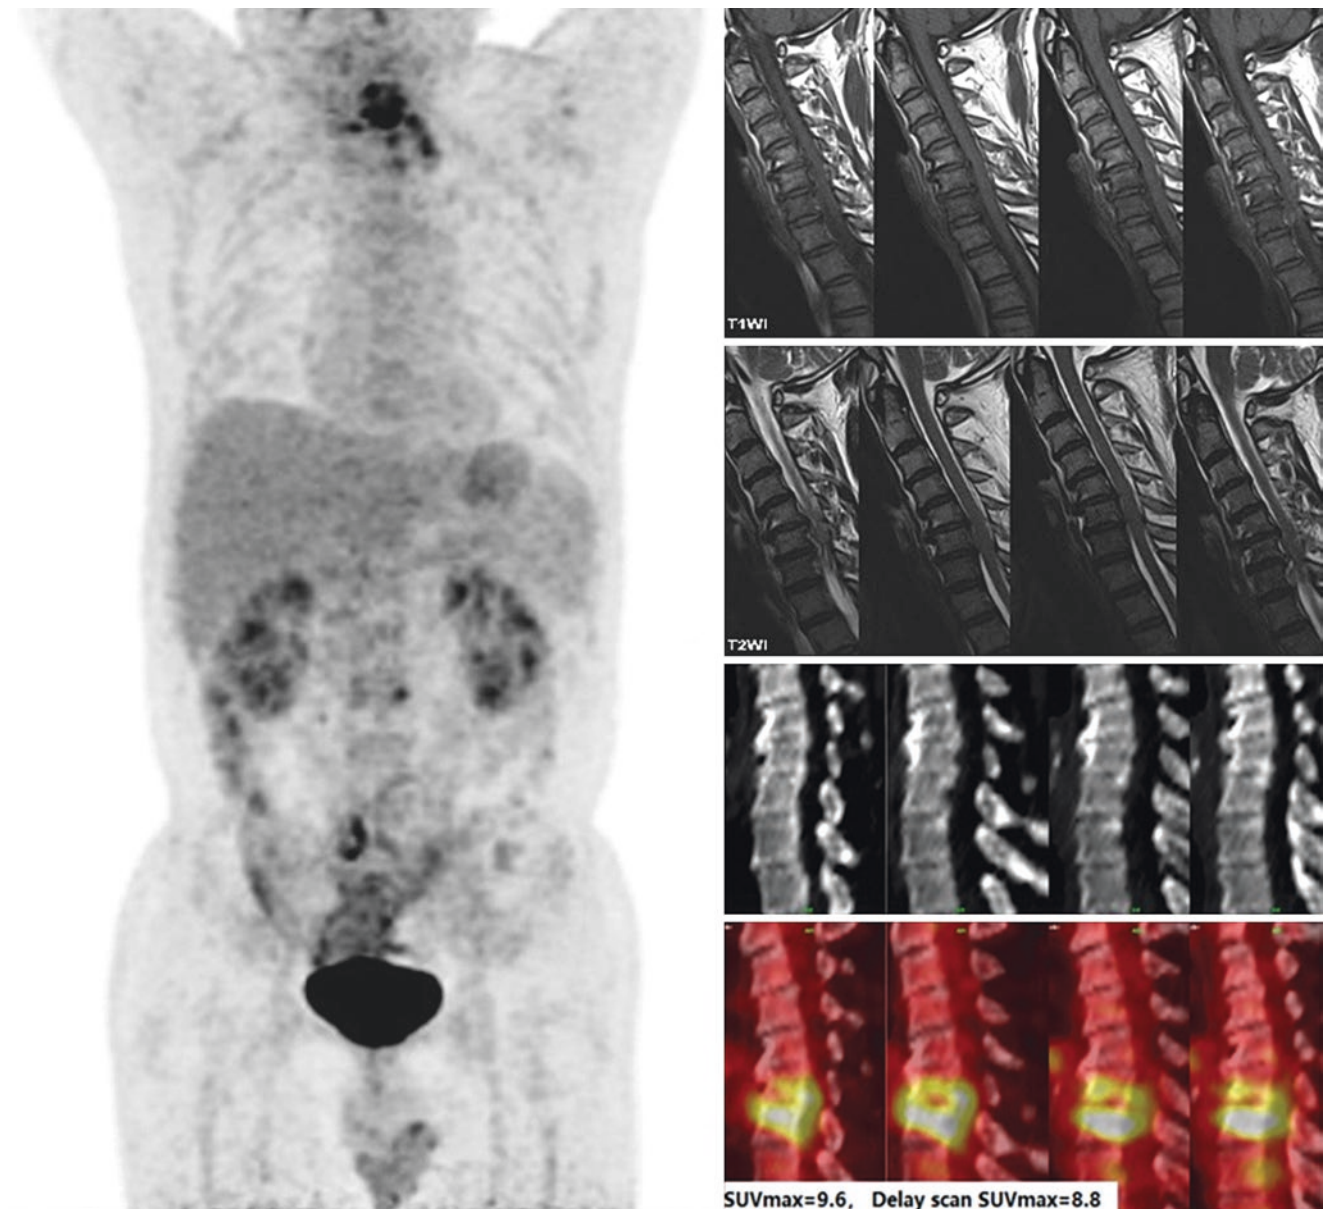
Images demonstrate increased FDG uptake for PET/CT images in the cervical vertebrae ($SUV_{max} = 9.6$), and the bone density of C6 and C7 vertebral bodies was uneven. MRI showed low T1WI
